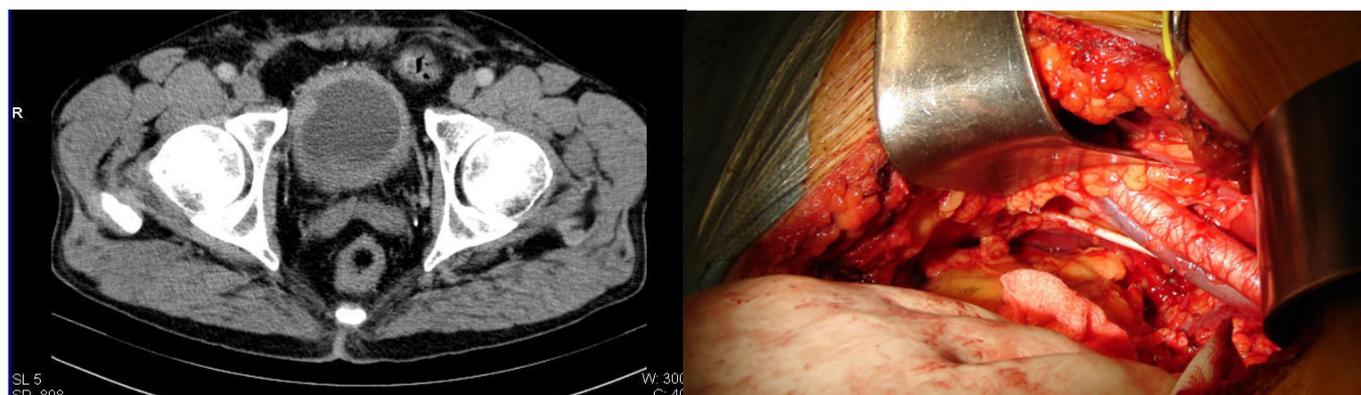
A. CT unifocal MIBC on right wall without pathological lymph nodes. B. Intraoperatory PLND on the right side
